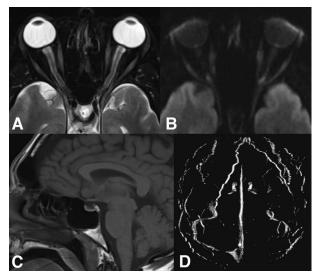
Case 1. MRI/MRV brain with signs of intracranial hypertension. (A) Axial MRI T2 image showing mild prominence of the CSF surrounding the optic nerves with protrusion into the posterior sclera, flattening of the posterior globes, and mild tortuosity of each optic nerve. (B) Axial MRI DWI image with faint diffusion restriction of the optic discs. (C) Sagittal MRI T1 image showing partially empty sella, with concavity of the superior pituitary margin. (D) Axial MR Venography three-dimensional reconstruction showing stenosis of the left > right transverse venous sinuses without evidence of venous sinus thrombosis. CSF, cerebrospinal fluid; MRV, MR venogram.
